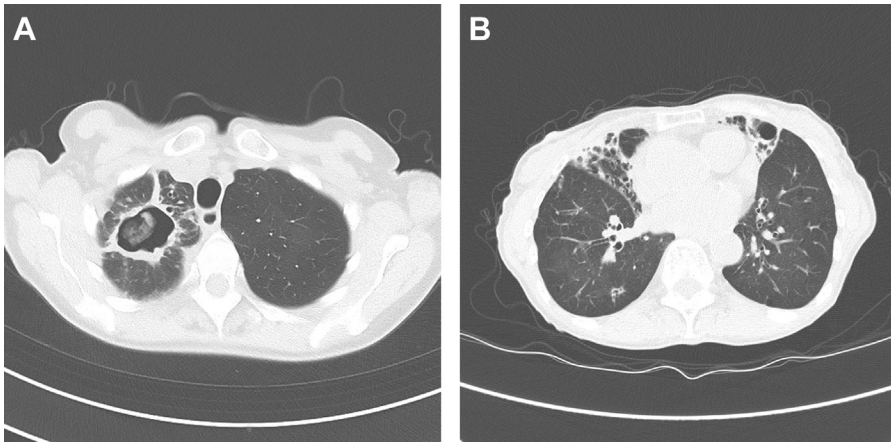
(A) Chest CT in a man with COPD and evidence of fibrocavitary NTM involving the right upper lobe containing a mycetoma, and with surrounding bronchiectasis and tree-in-bud nodularity. (B) Chest CT in an elderly woman with noncavitary NTM involving the middle lobe and lingula (a common distribution).
